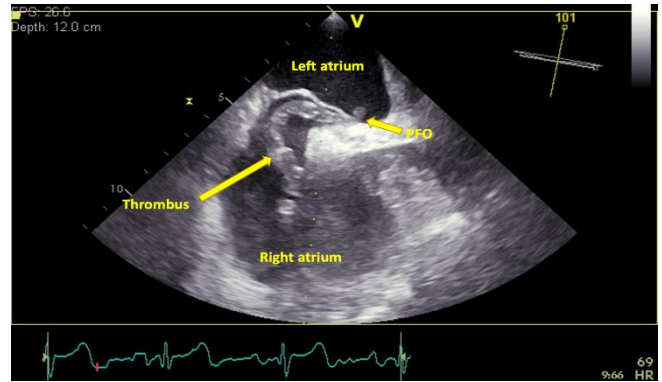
Transesophageal echocardiography in a 101° view. A large and mobile thrombus is seen across the foramen ovale.
